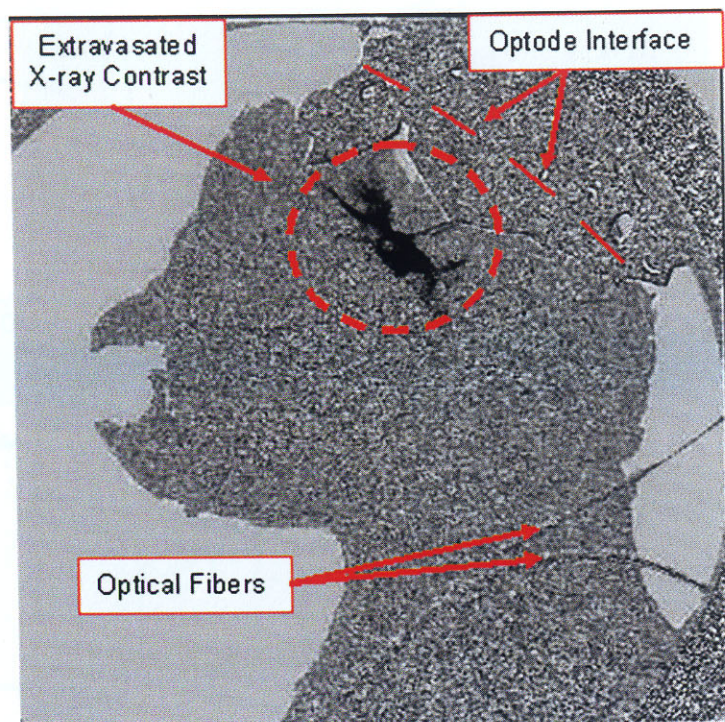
Lateral DSA demonstrating right ICA perforation and SAH prior to subsequent occlusion. Dark material is extravasated X-ray contrast agent
